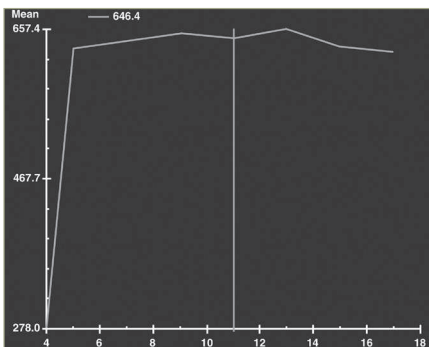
Medullary carcinoma appears as a rounded well-defined lesion homogeneous contrast enhancement on MRI.
